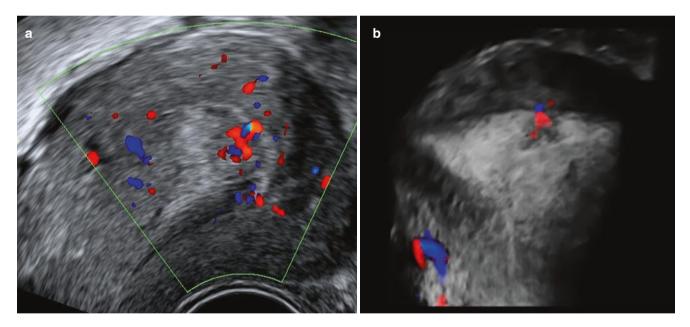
Hypoechoic polyp with a feeder vessel approaching it from the uterine fundus on (a) Doppler and (b) 3D with glass body rendering
